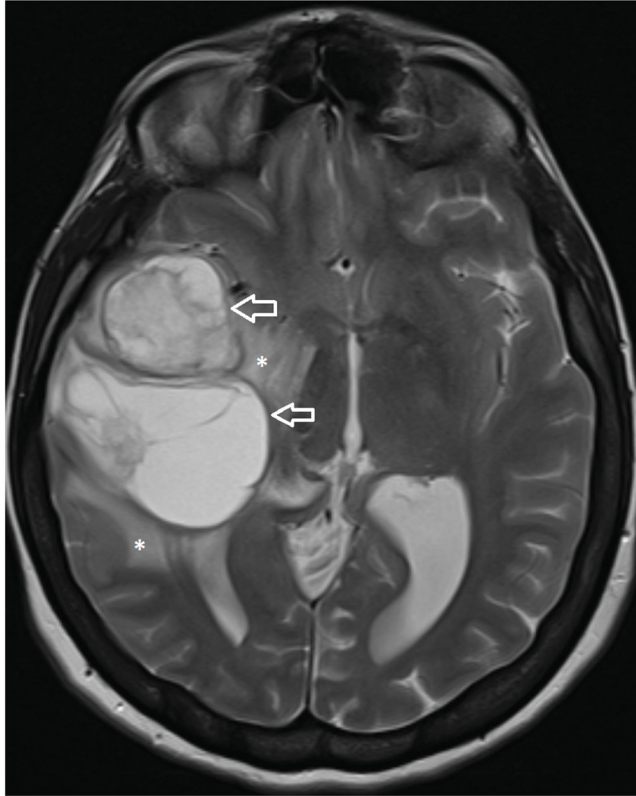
Axial T2-weighted magnetic resonance imaging shows two adjacent cystic lesions (arrows) with white matter edema (stars) in the right frontotemporal region.
